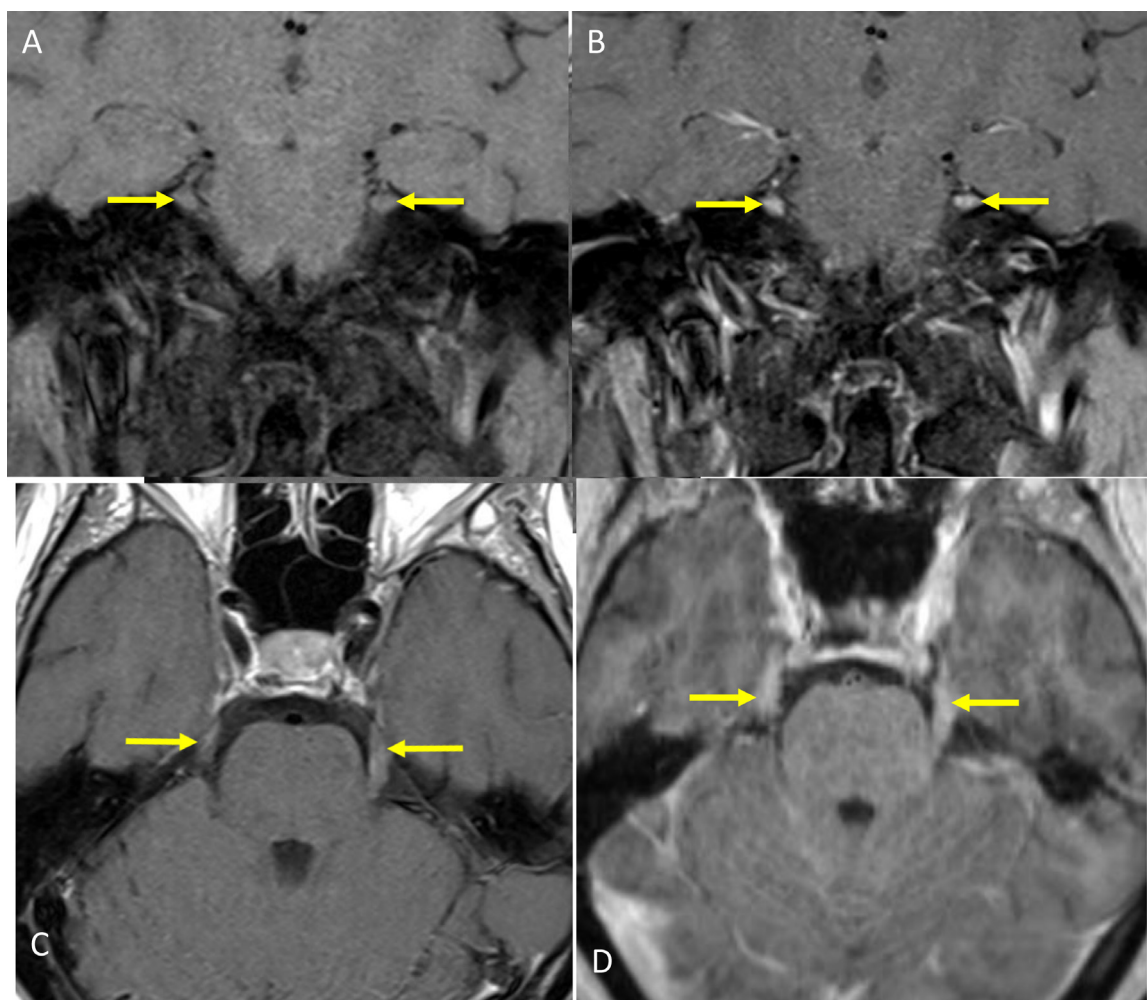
Pre-contrast (A) and post-contrast (B) coronal T1-weighted images with fat-saturation and axial post-contrast T1-weighted image (C) and axial T1-weighted post-contrast MPRAGE image (D) show enhancement of the cisternal portions of the 5thth cranial nerves extending into the porus trigeminus bilaterally. (arrows).
